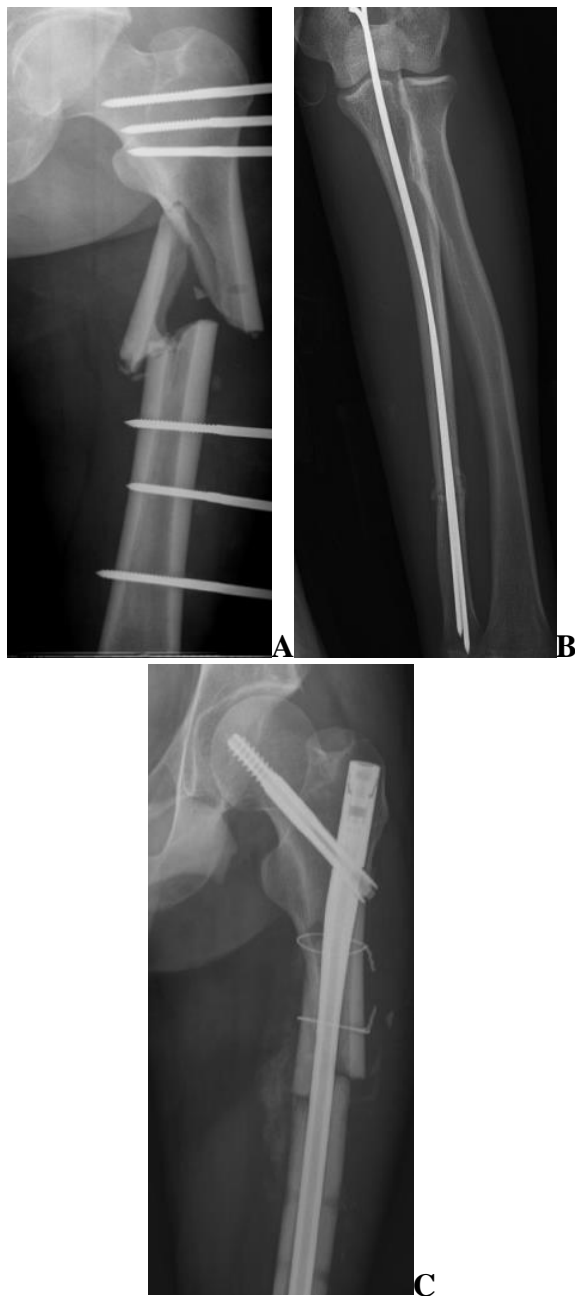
Case 1: Postoperatively imagistic evaluations; A- femur external fixator, B- cubitus osteosynthesis X-ray, C- femur osteosynthesis Gamma Nail X-ray
